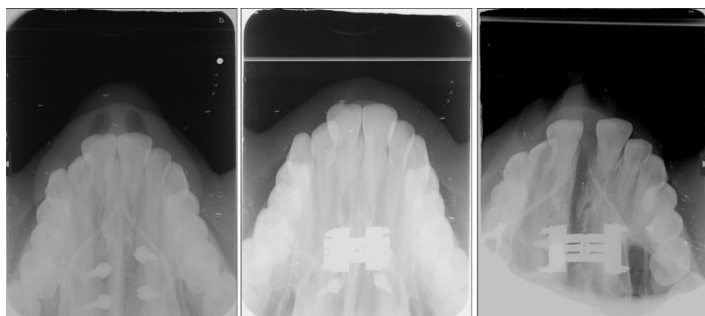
Occlusal radiography recordings taken from the patient.
